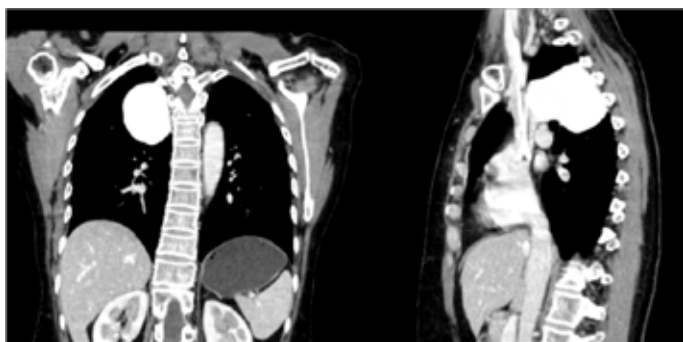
Contrast-enhanced chest CT showed a well-defined low-attenuation mass in the right thoracic cavity adjacent to the mediastinum, showing contrast enhancement and continuity with the azygos vein.
